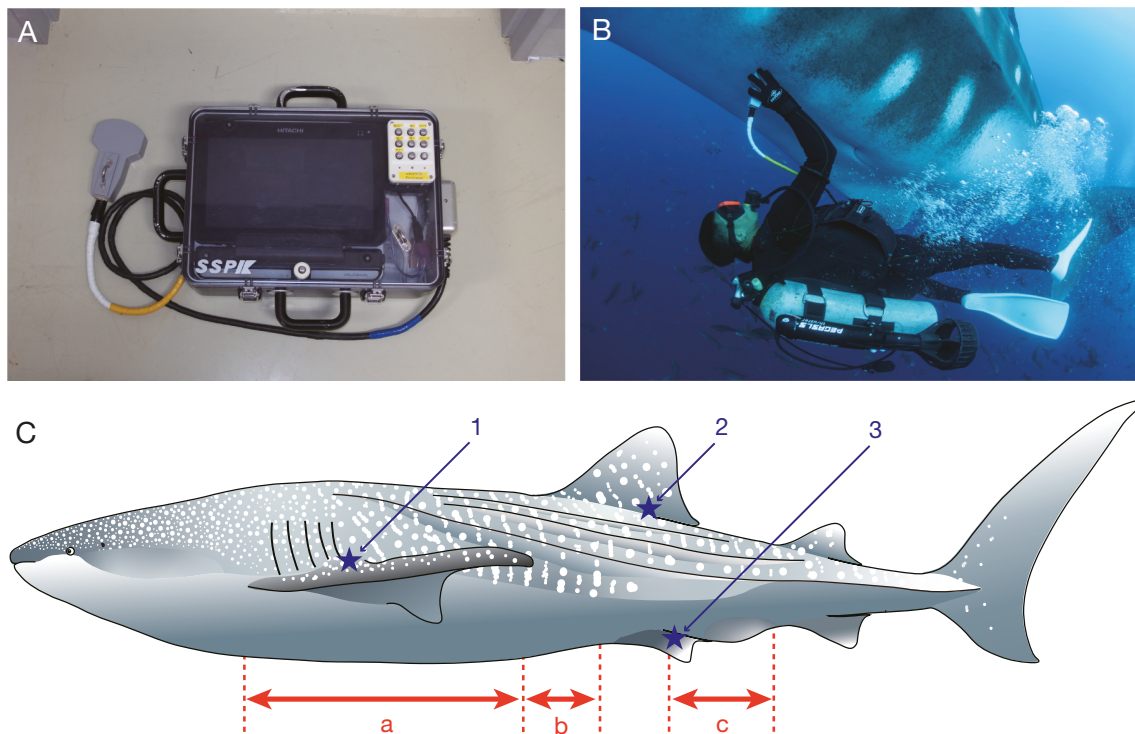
(A) Ultrasound diagnostic imaging system (ARIETTA Prologue) housed in a pressure- and waterproof case. (B) SCUBA diver positioning the ultrasound probe on the ventral surface of a free-swimming female whale shark in the Galapagos. (C) Ultrasound probe scanning areas (double-headed arrows) and blood sampling locations (stars). a: abdominal area; b: anterior part of pelvic fins; c: post-pelvic distention; 1: pectoral dorsal vein (easy to collect on juveniles); 2: first dorsal cutaneous vein (difficult to collect, but possible on all shark sizes); 3: pelvic dorsal vein (easy to collect on adult sharks)
